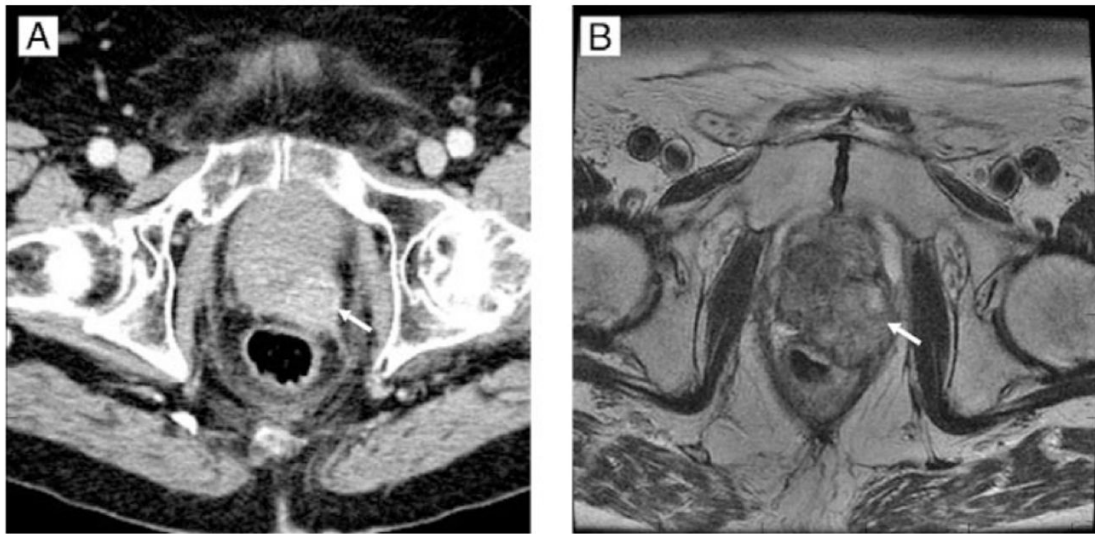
Advanced prostate cancer. Prostate CT and corresponding MR. a: CT image of the prostate using early-phase intravenous contrast. b: Corresponding axial T2W MR at 1.5T, obtained using a body coil but no endorectal coil. White arrows indicate a focal tumor in the left posterior region of the prostate.
